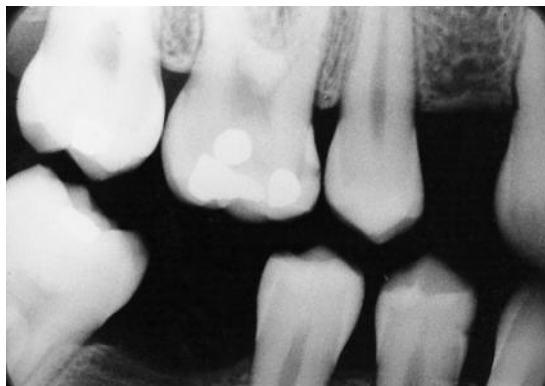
A bitewing radiograph showing caries in enamel and dentine on the mesial aspect of the upper first molar. A lesion is also visible on the mesial aspect of the lower first premolar.
